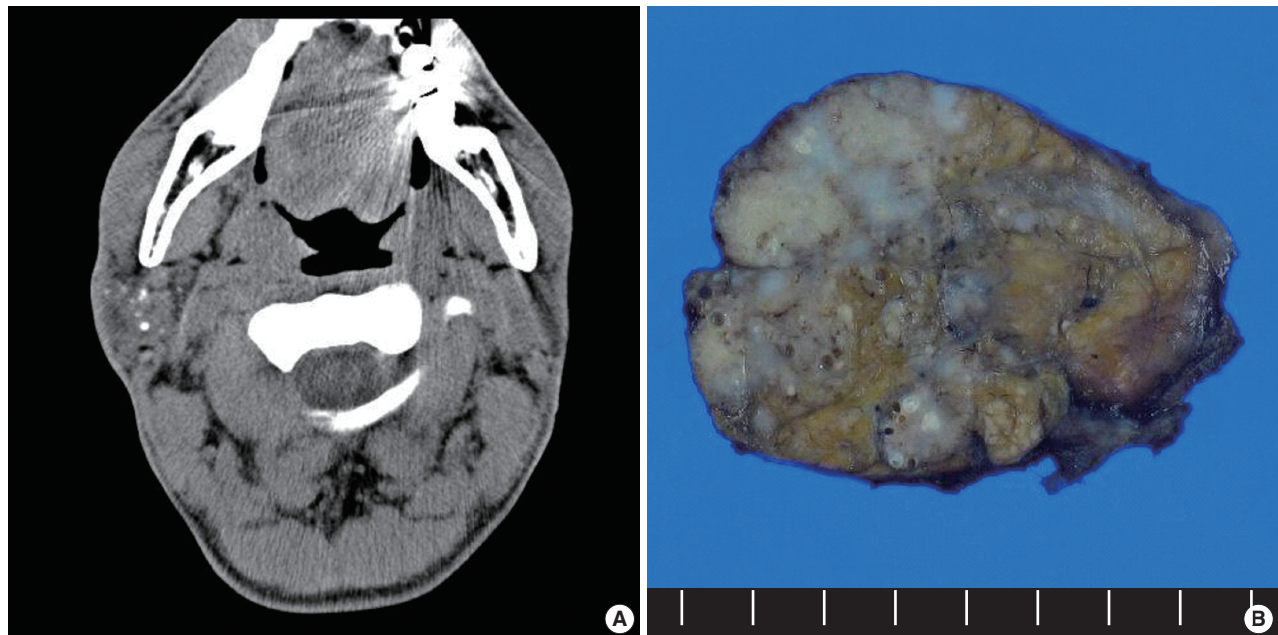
(A) Post-contrast computed tomography of the neck shows a heterogeneously enhancing mass with multiple small calcifications in the right parotid gland. (B) Three cm diameter, poorly circumscribed solid tumor with small cysts. The cut surface shows lobulated sclerotic nodules composed of fibrocollagenous stroma and calcification.
